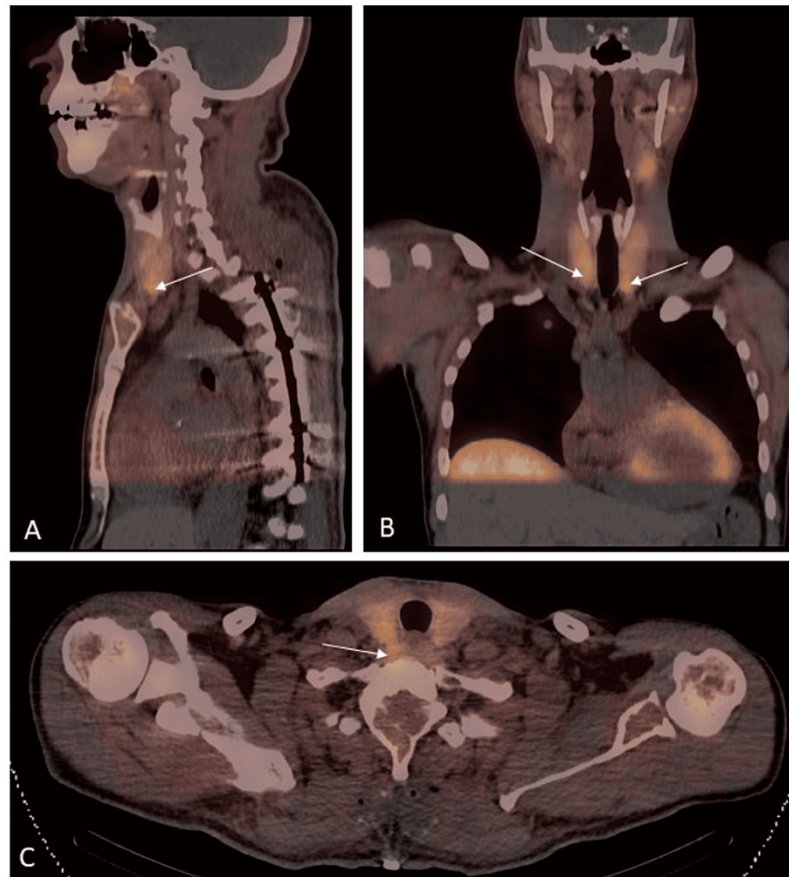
Sagittal (A), coronal (B) and axial (C) SPECT-CT images at 20 minutes. Focal increased uptake at the lower aspect of the right and left thyroid lobes (white arrows) suggests hyperplasia of bilateral lower parathyroid glands.
